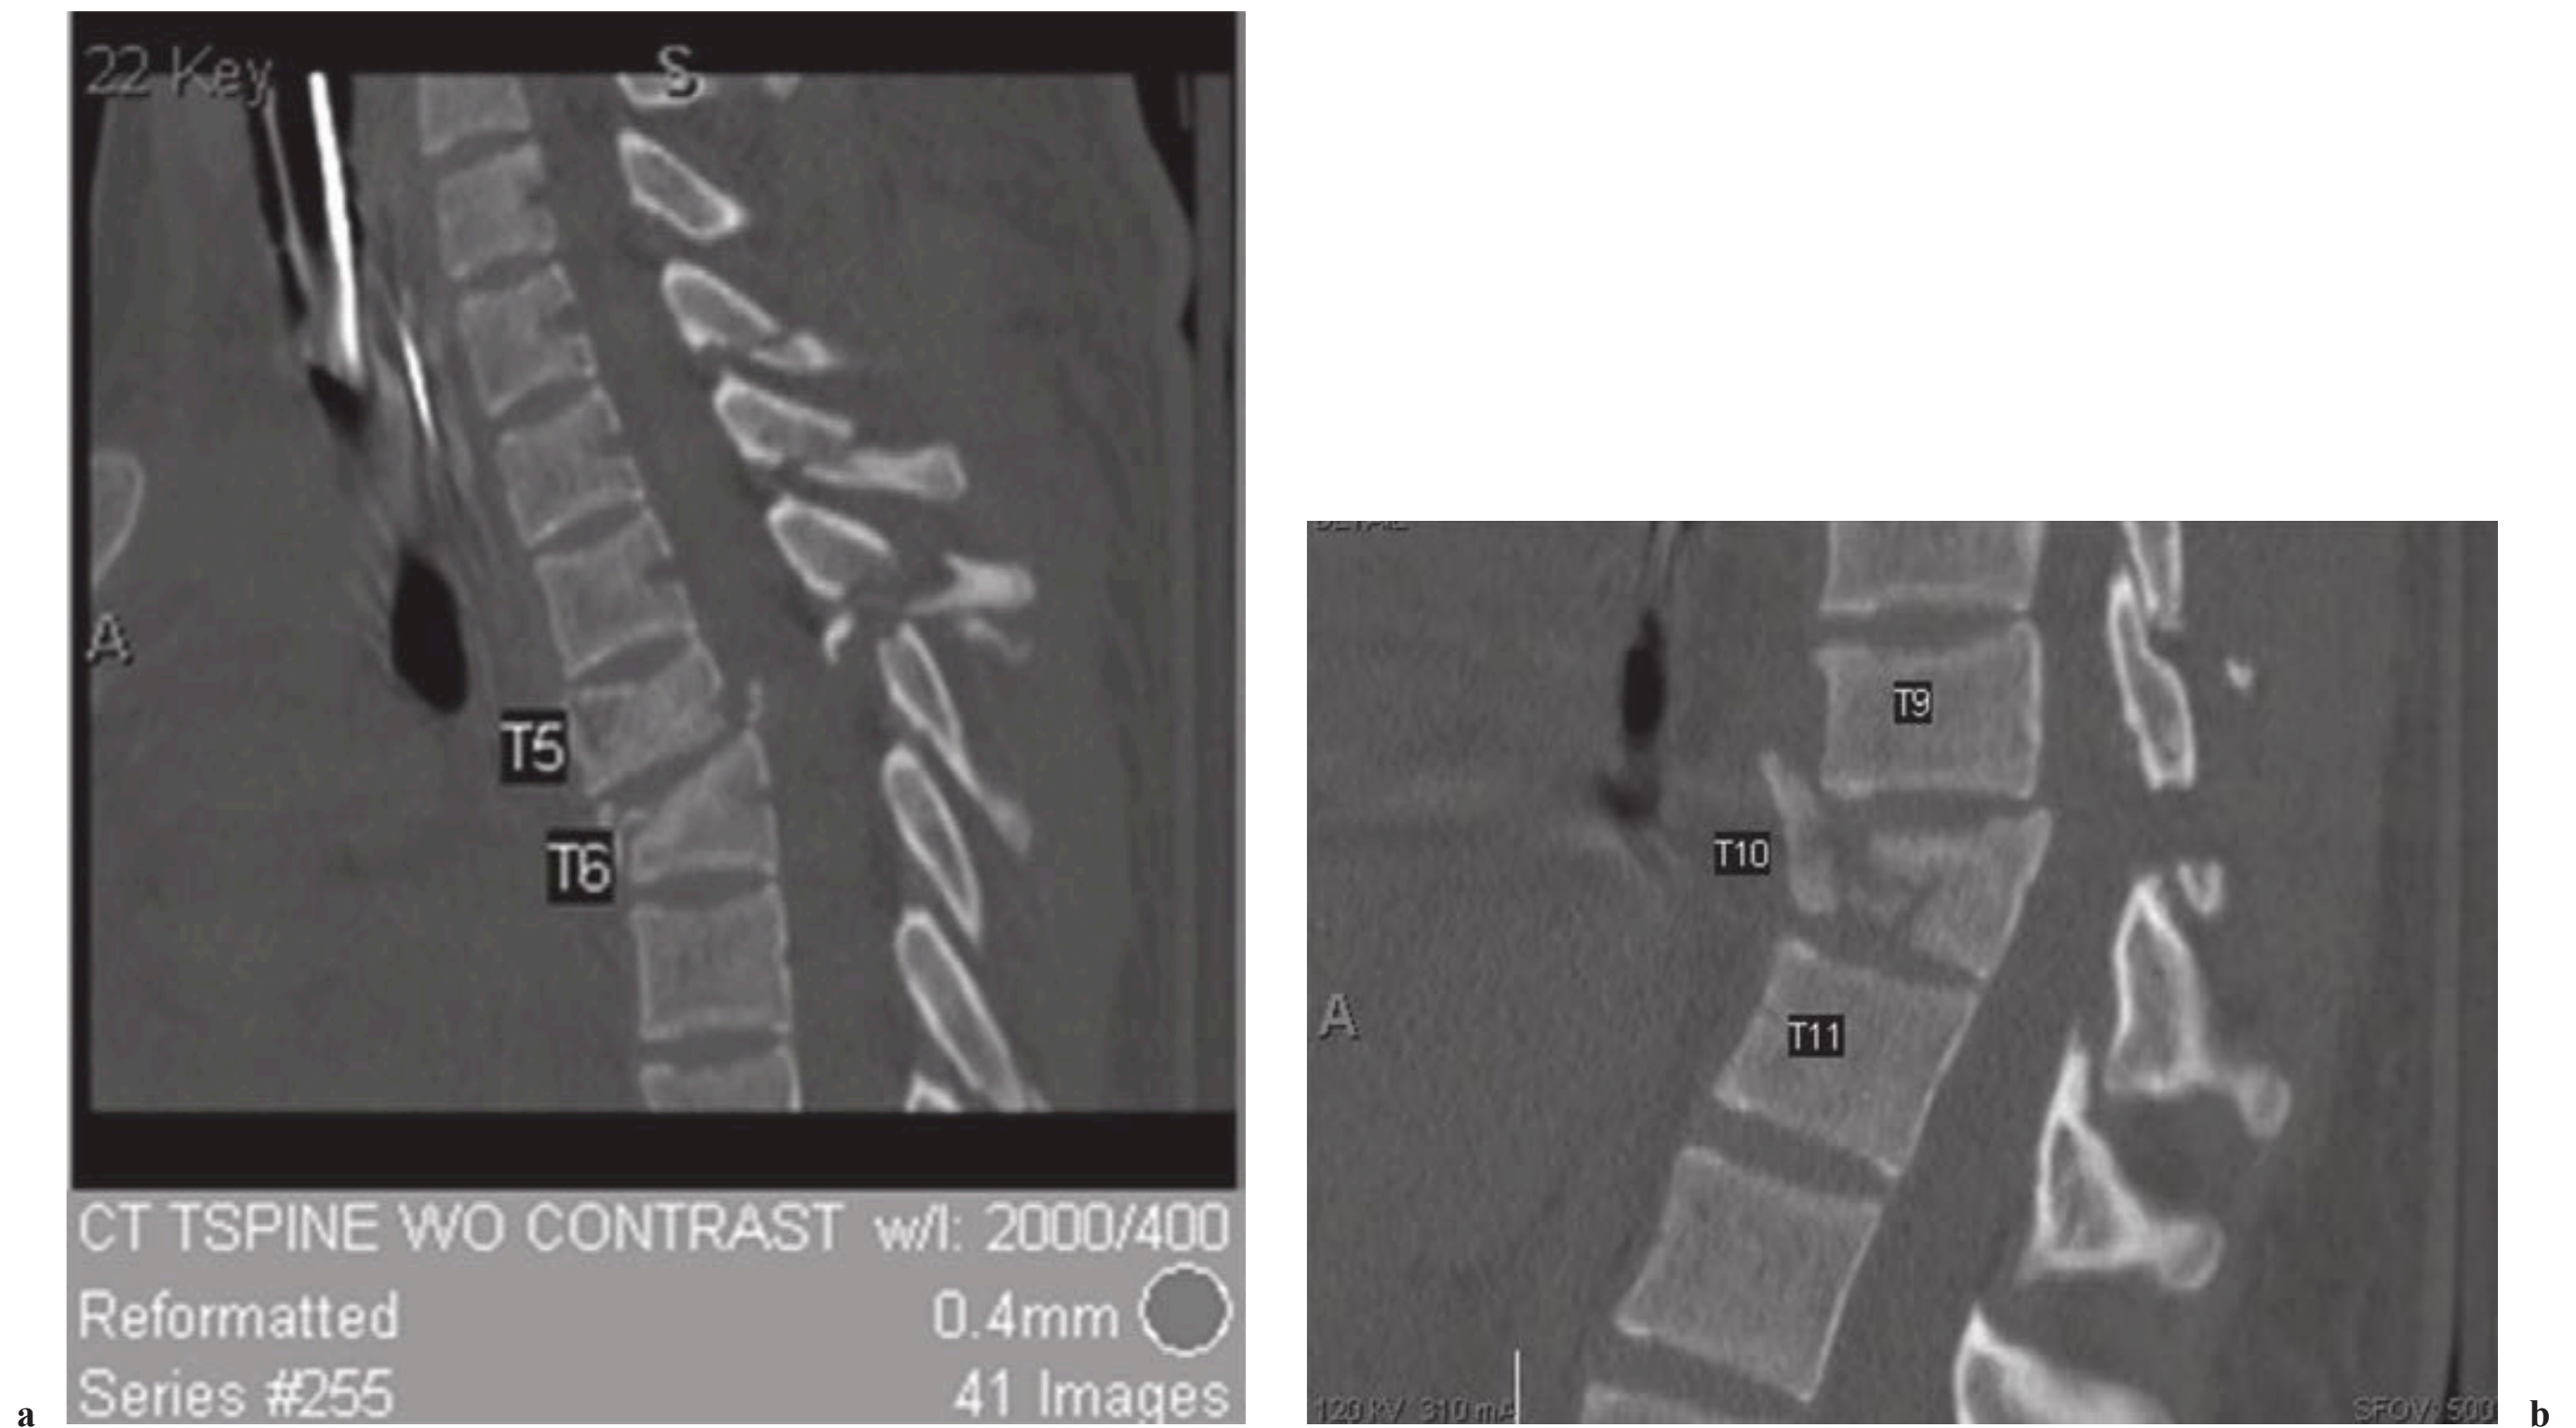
Sagittal CT reconstructions of an 18-year-old woman who was involved in a motorcycle accident, sustaining thoracic fracture demonstrating (a) T6 and (b) T10 burst fractures with kyphotic angulation. (a) In addition, at the T5-6 level she had a fracture-dislocation with T5 laminar and spinous process fractures. The patient was able to move her lower extremities with some sensation. However, due to the fact that she had grossly unstable spine, she was kept on bedrest until surgical stabilization could be performed.
